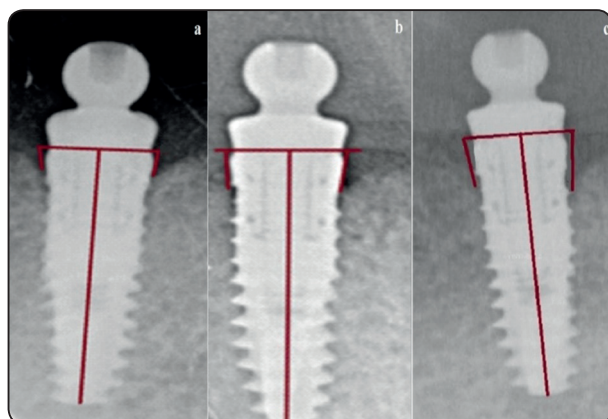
Radiographic measurements for platform switched implant. a; MBL after 1 year, b; MBL after 2 years and c; MBL after 3 years.
